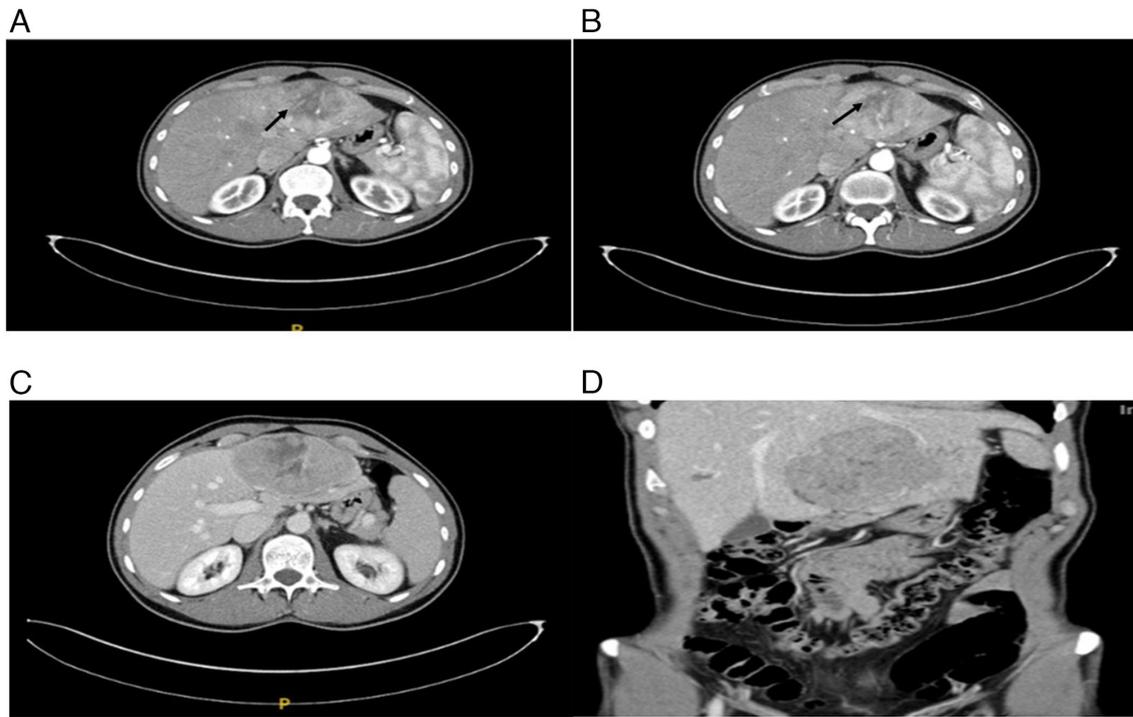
(A) Dynamic multi-slice contrast-enhanced CT imaging demonstrated a well-circumscribed (arrow), hypervascular mass in the left lobe of the liver. (B) Dynamic multi-slice contrast-enhanced CT imaging revealed that the lesion showed heterogeneous enhancement in the arterial phase, with progressive washout (arrow) or persistent enhancement in the portal venous and delayed phases. (C) Dynamic multi-slice contrast-enhanced CT imaging: The lesion was inhomogeneous, peripherally hypervascular and showed partial washout in the portal venous phase. (D) Dynamic multi-slice contrast-enhanced CT imaging delineated the tumor within the left lobe of the liver and its spatial relationship to adjacent organs.
